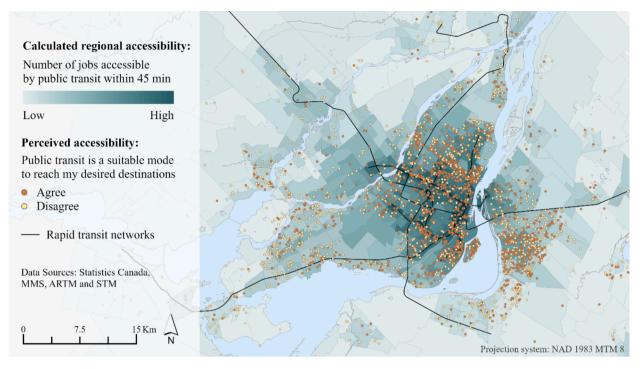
Accessibility by public transit in 45 min at the CT level and perceived accessibility by public transit for 2,985 survey respondents.
